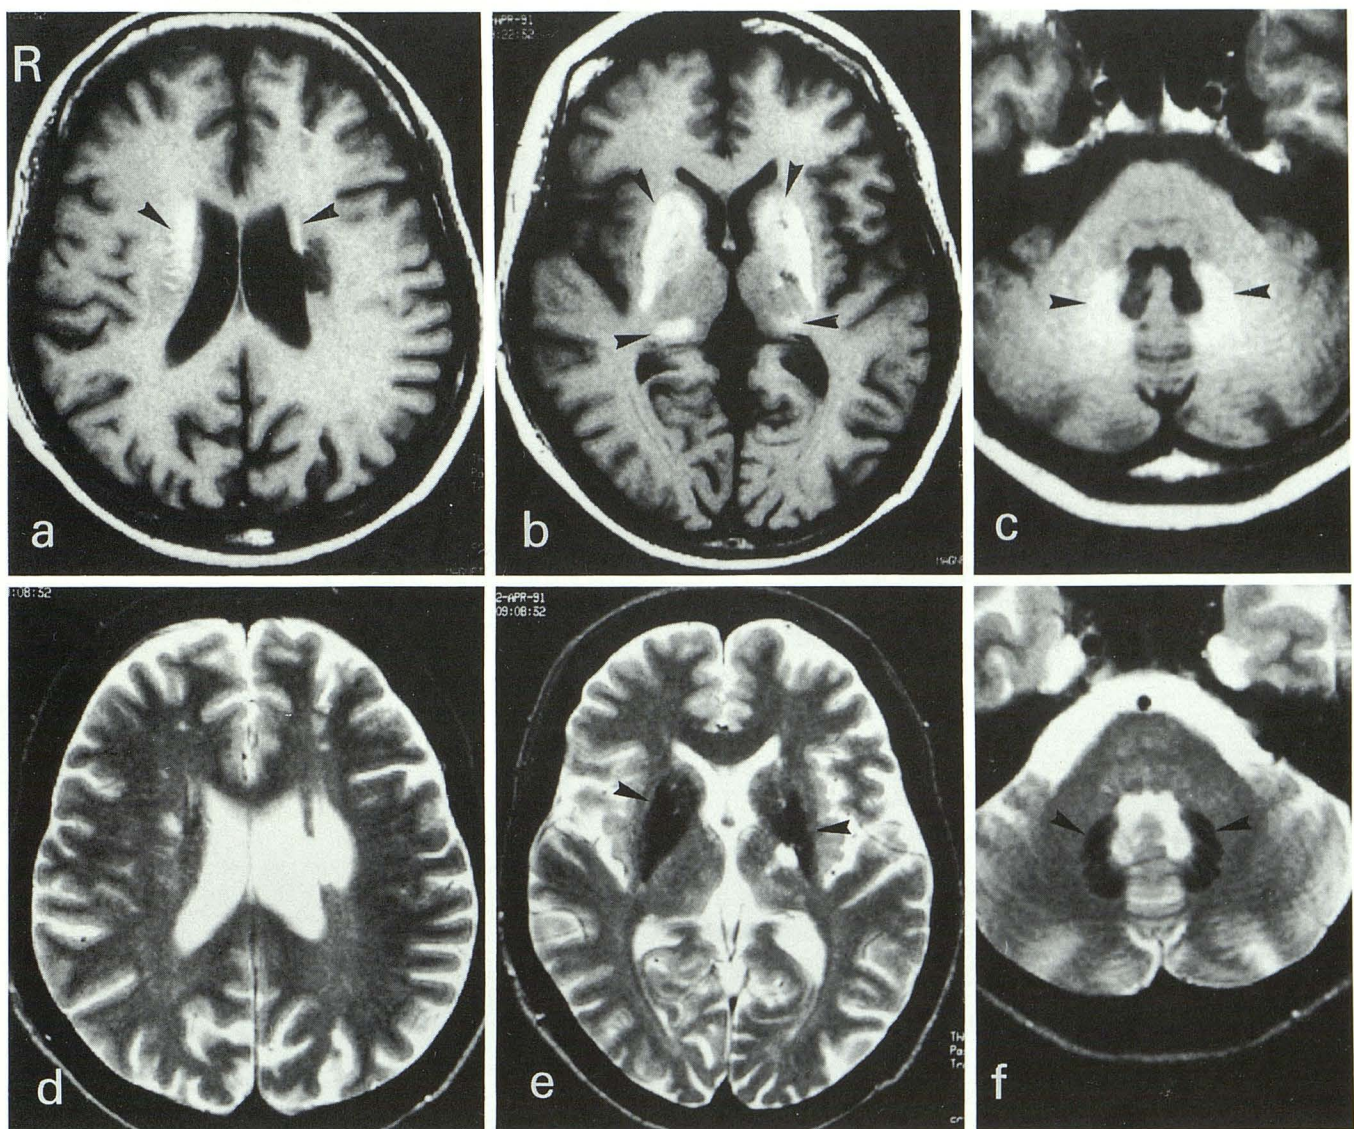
MR in April 1990 showed old cerebral infarctions in the left corona radiata, internal capsule, and the bilateral frontal deep white matter. T1-weighted images (a, b, c) showed abnormal high signal intensity areas in the putamina, caudate nuclei, pulvinar, cerebellar white matter, and dentate nuclei bilaterally (arrowheads). The distribution of high signal was almost identical to the distribution of calcification on CT. However, the bodies of caudate nuclei with little calcification on CT showed apparently high intensities (a, arrowheads). T2-weighted images (d, e, f) showed abnormal decreased-intensity areas in the putamina, caudate nuclei, and dentate nuclei bilaterally (arrowheads).
